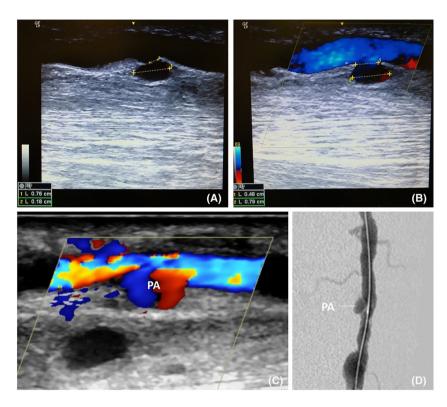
(A-C) B-mode and color-Doppler ultrasound images revealing a pseudoaneurysm (PA) with about 7.9-mm diameter and a 4.8-mm neck. (D) Baseline angiography showing contrast extravasation into the pseudoaneurysm
